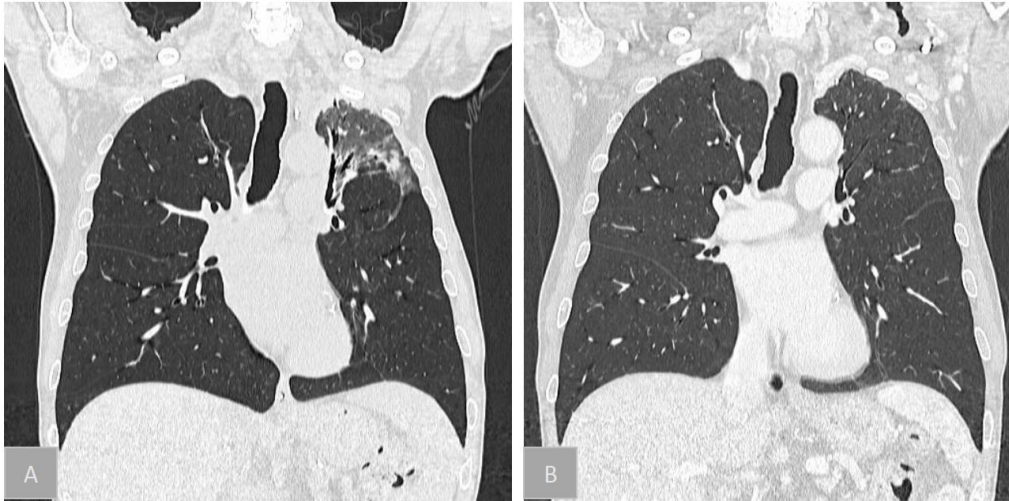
A) October 26th Chest CT scan (lung window), showing a clearing left upper lobe with marked decreased in extension of pulmonary consolidation 1 B) 20th February 2024 Chest CT scan (lung window) showing complete resolution of pneumonia.
